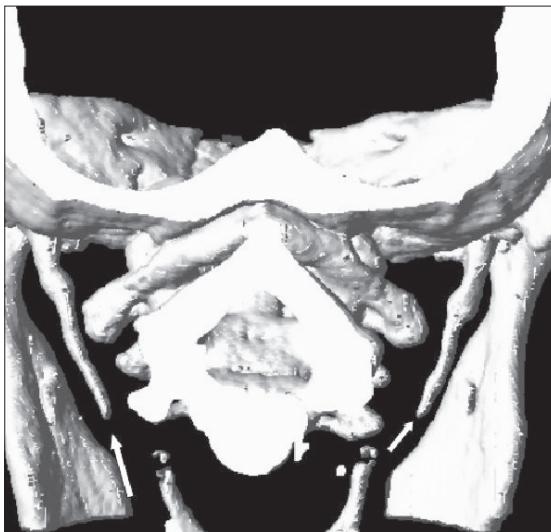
3D-CT image. The left styloid process (41.1 mm) (*long arrow*) is slightly longer than the right (40.2 mm) (*short arrow*) in a 35-year-old woman.
